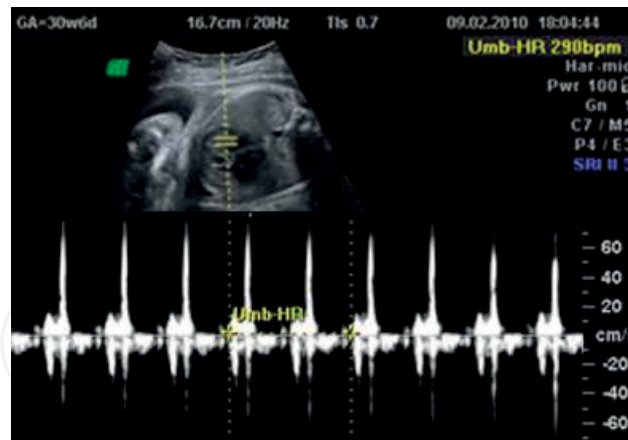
Tachyarrhythmia and measurement of cardiac rhythm using pulsed Doppler.
